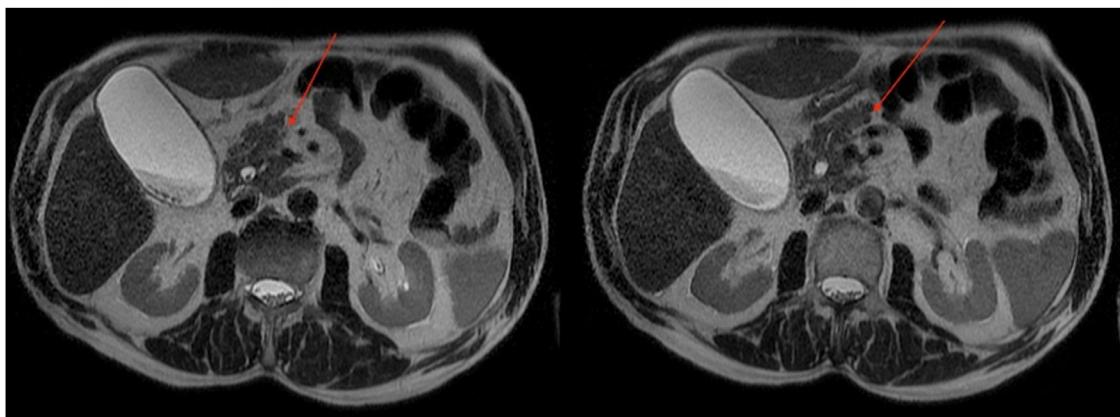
MRI confirms the CT scan evidence of partial dorsal agenesis of the pancreas and the presence of luminal prepapillary non-obstructive filling defect.
